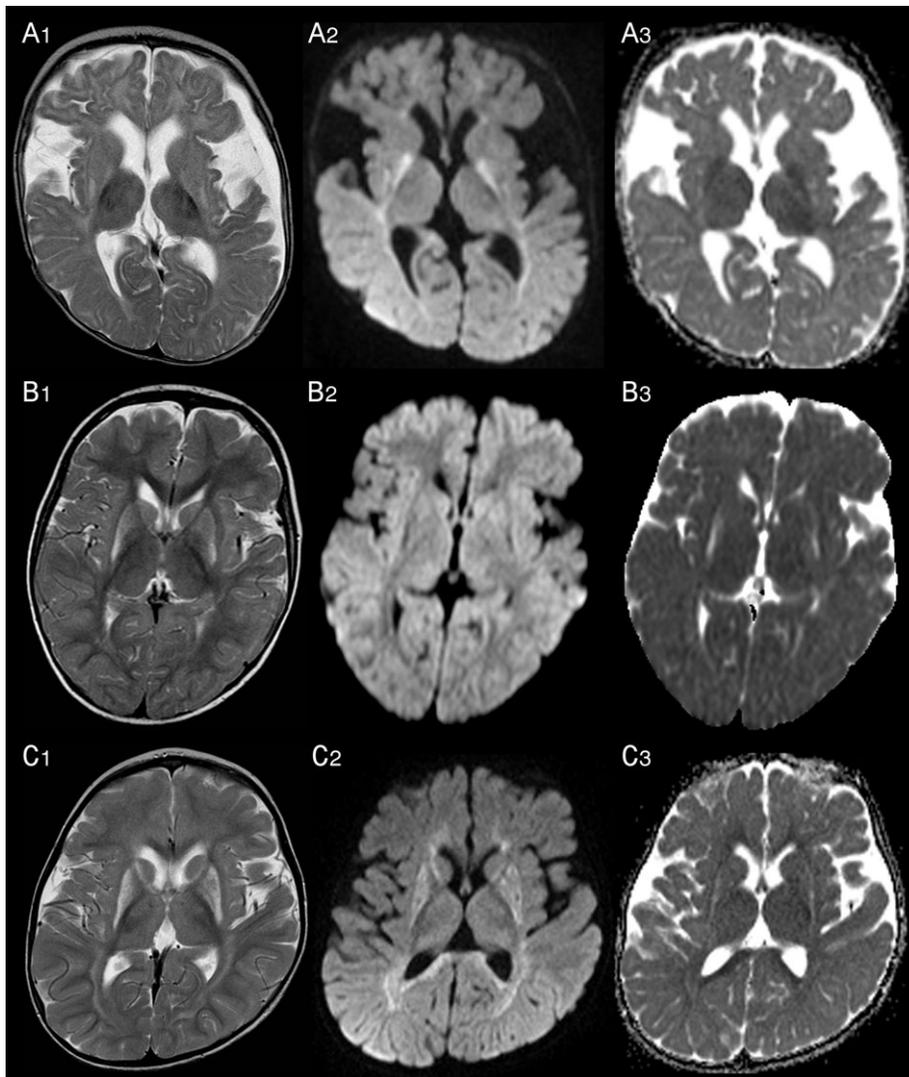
Pattern of sequential striatal injury in insidious-onset patients with progressive dystonia [each row displays from left to right T2-, corresponding diffusion-weighted image (DWI) and apparent diffusion coefficient (ADC) map annotated with 1,2,3, respectively]. A, B Following AEC, the pre-existing lesions of the dorsolateral putamen in patients 10 (A) and 11 (B; see also Figure 2G₂, H₁) are more T2-hyperintense and diffusion is more highly elevated than in the remaining, newly affected striatum with its mild T2-hyperintensity and mildly elevated diffusion. C Extensively T2-hyperintense striatum in the single MRI of patient 8 imaged after deterioration; DWI reveals sequential injury with clearly elevated diffusion of older, pre-existing lesions of the dorsolateral putamen and mildly elevated diffusion of the more recently injured, remaining striatum
